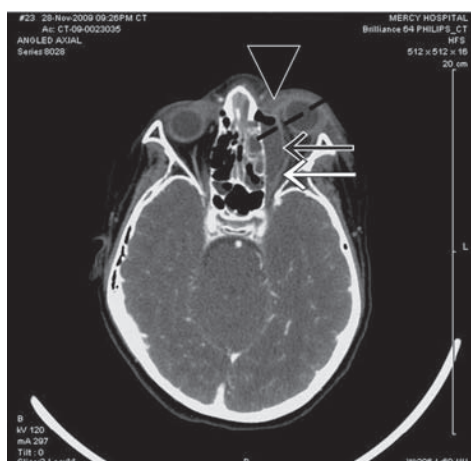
Axial view of contrast-enhanced CT scan demonstrating (black arrow) extraconal orbital subperiosteal abscess with air-fluid collection along the medial and anterior walls of the maxillary sinus with (white arrow) associated lateral displacement of the left medial and inferior recti, (arrowhead) left preseptal cellulitis with proptosis, (dotted line) left maxillary and ethmoid sinusitis.
